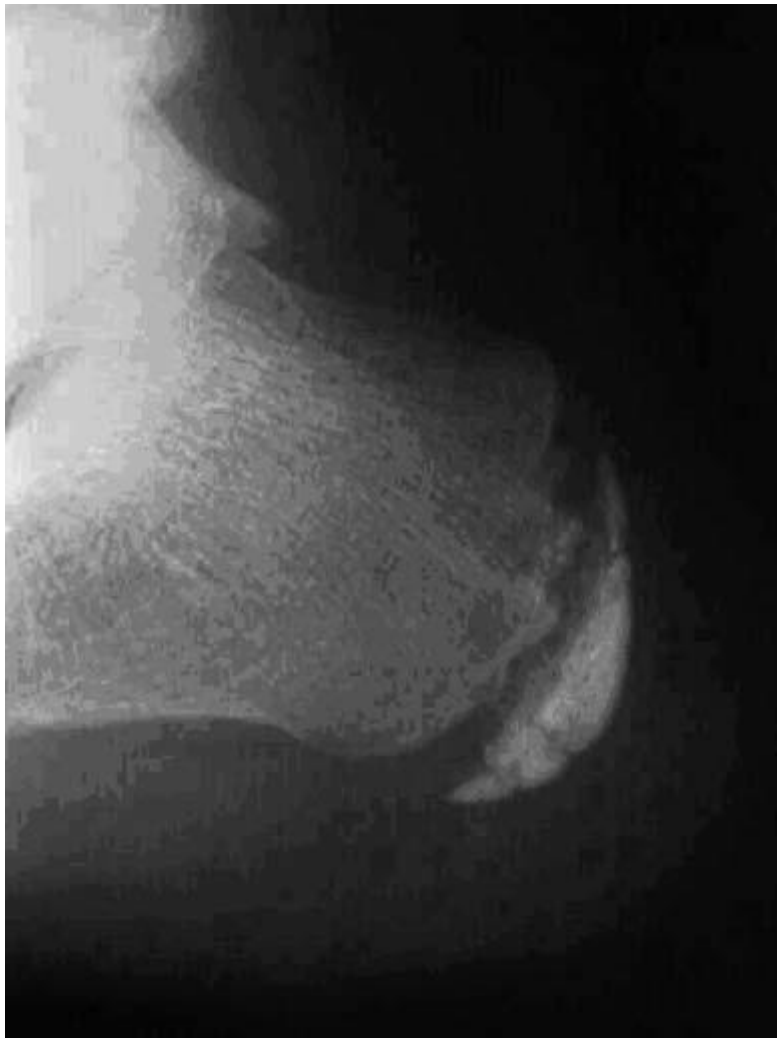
Lateral x-ray view of young athlete with calcaneal apophysitis. (www.e-radiography.net, 2012)
